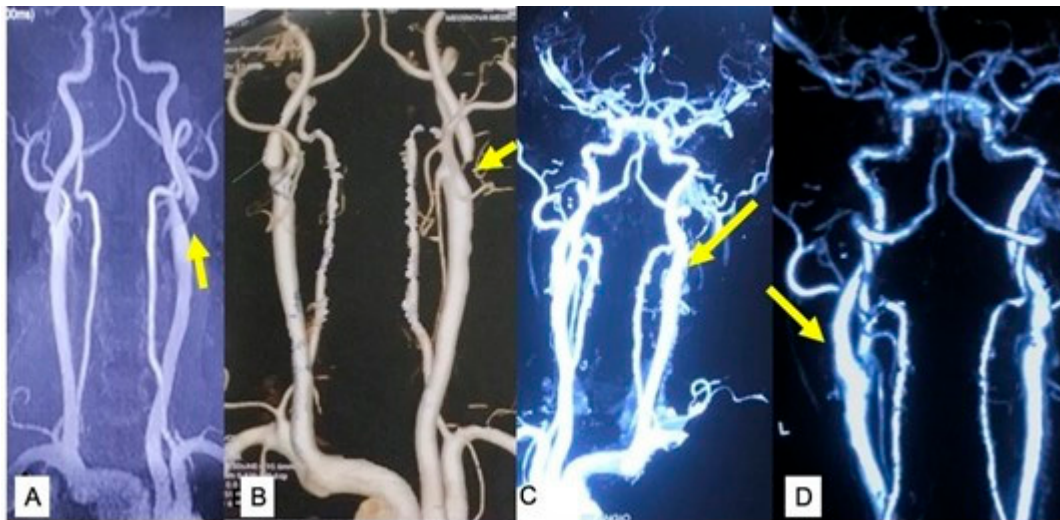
(A) Preoperative MRA showing a high-grade ICA stenosis on the left side. (B) Preoperative CTA of the same patient showing the same ICA stenosis. (C,D) Postoperative CTA on the 1st POD after a CEA of the same patient showing relief of left ICA stenosis. Source: Figure by authors.
